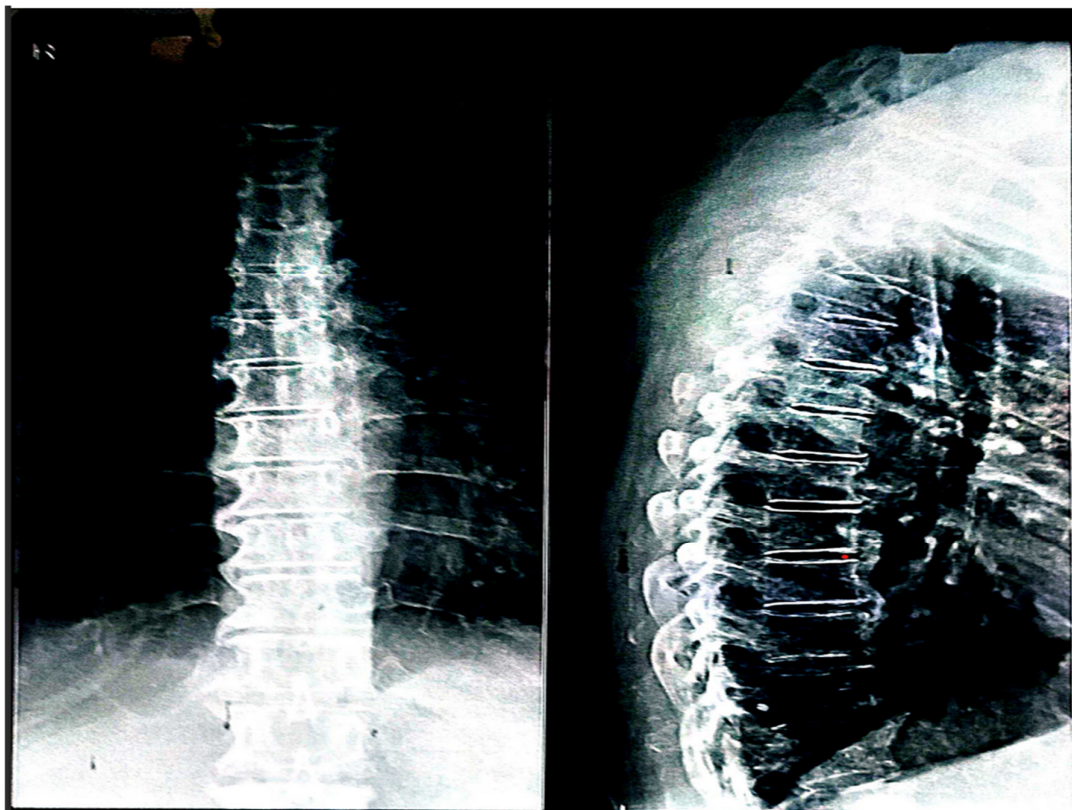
X-Ray Thoracic Spine AP/LAT View
